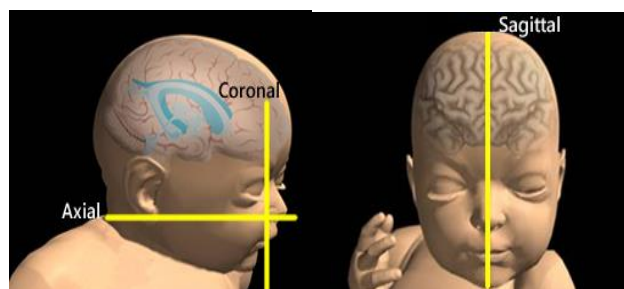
MRI orientations in Axial, Coronal & Sagittal plane [65]
